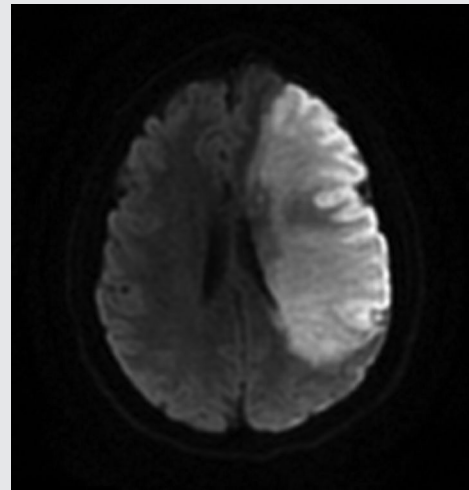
Diffusion-weighted imaging MRI photograph of patient's ischemic stroke.
